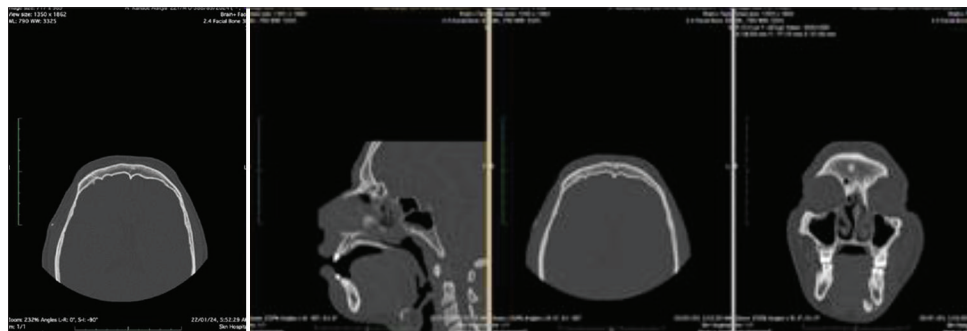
Agger nasi cell (anteroinferior to frontoethmoid recess) is best visualized in the coronal plane on CT
